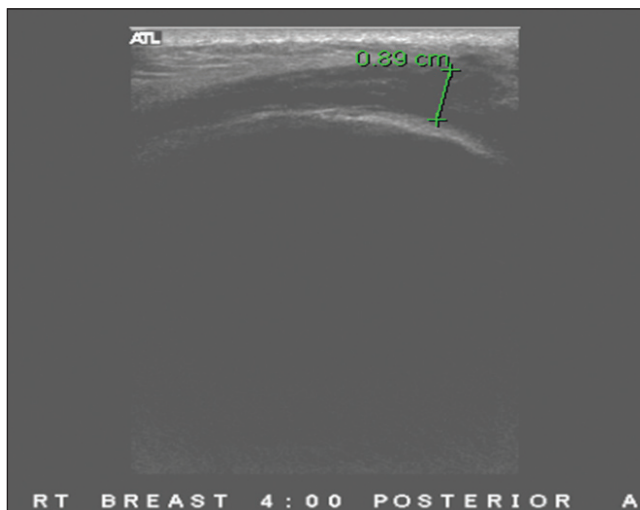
Right breast ultrasound demonstrating a curvilinear fluid collection anterior to the implant and the overlying tissue of unclear consistency
